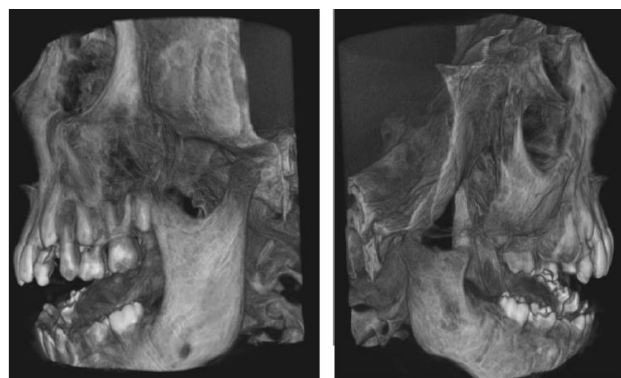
CBCT Scan images.
